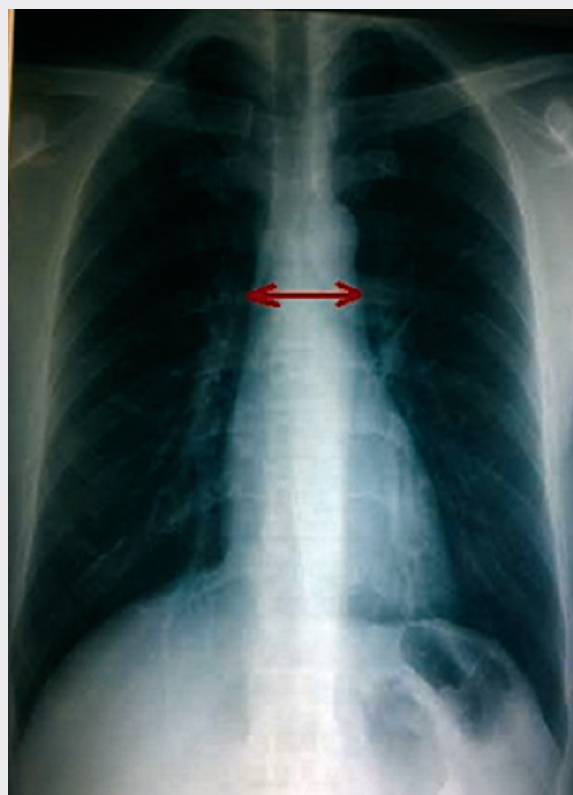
Enlargement of the middle mediastinum on the chest radiography (red arrow) with no associated pulmonary parenchymal abnormalities.
